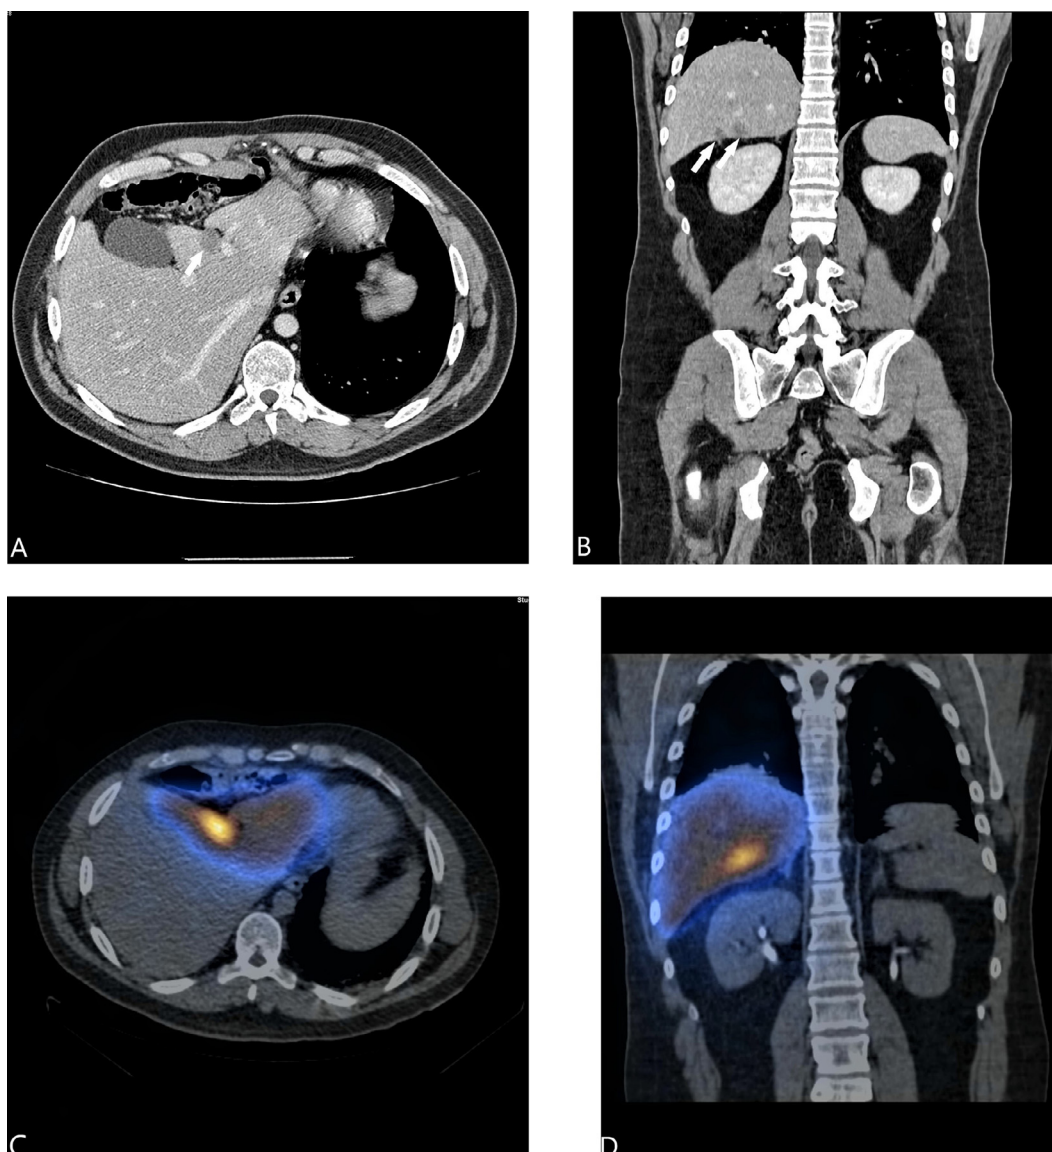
Contrast-enhanced CT showing segment 4 (arrow) and segment 5/6 (2 arrows) hepatic lesions on axial and coronal images (a, b). Post yttrium 90 radioembolization SPECT/CT demonstrating targeted radiotracer accumulation (arrow) within these lesions (c, d).
